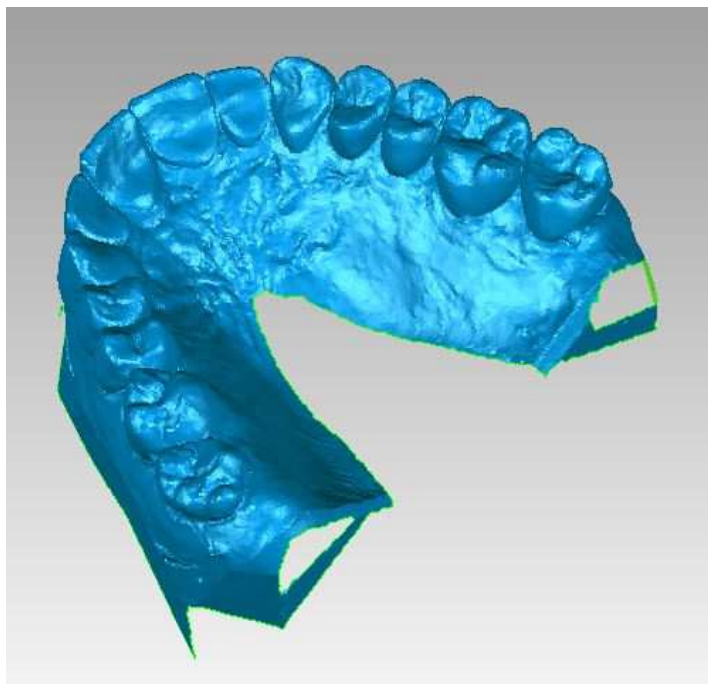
PROSPECTIC VIEW OF THE MESH BEFORE HOLE CLOSING TOOL
